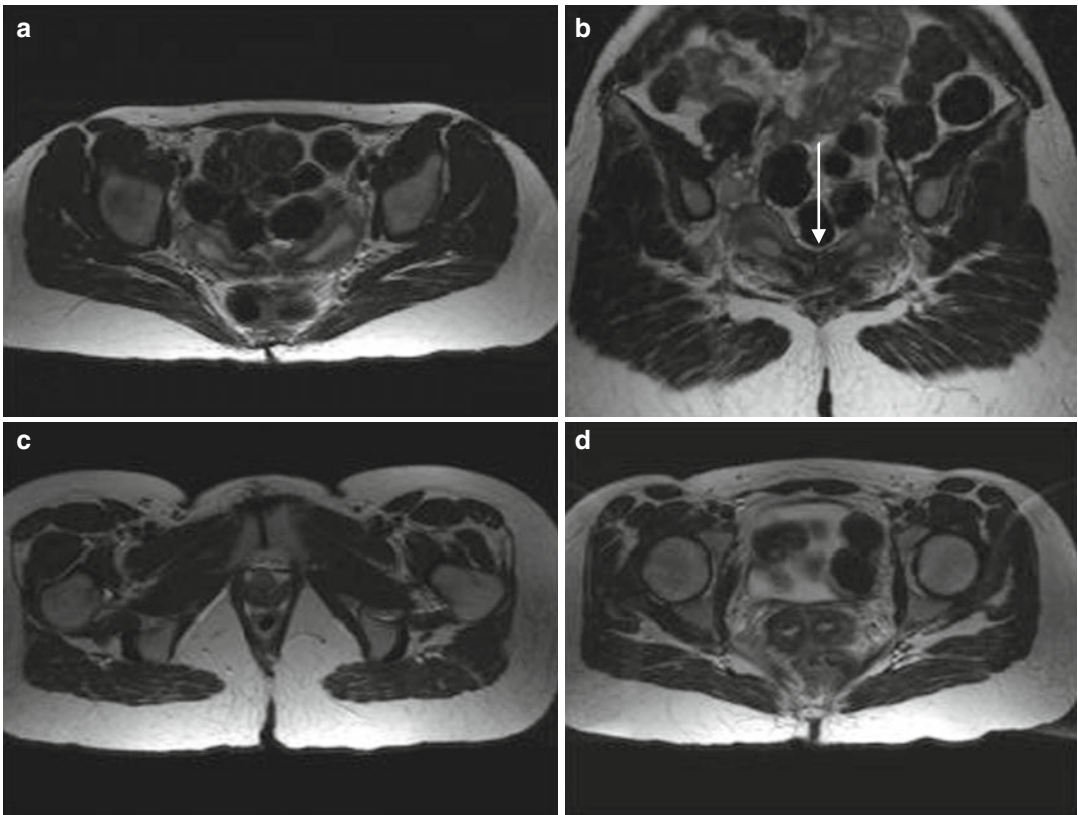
Didelphys uterus (III). Fast spin-echo T2-weighted images on axial (TR/TE 2800/110) (a, c, d) and coronal plane (TR/TE 4070/94) (b) show two divergent horns with duplicated cervixes in close apposition
